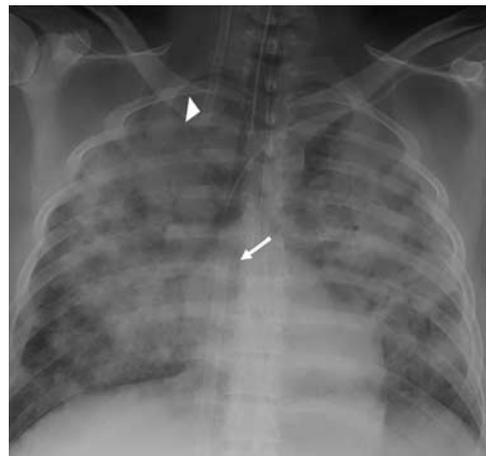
Veno-venous (VV) ECMO: frontal radiograph depicting VV-ECMO cannulae in the SVC (white arrowhead) and RA (white arrow) in a patient with respiratory failure due to massive aspiration.
